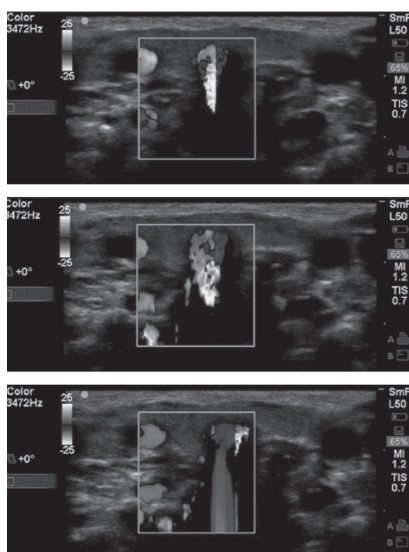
Color line in trachea taken using color Doppler
